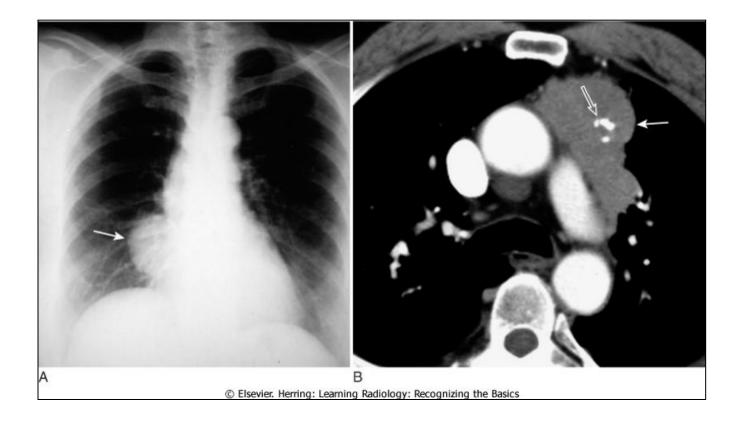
Thymomas, conventional radiograph (A) and CT scan (B). Thymomas are neoplasms of thymic epithelium and lymphocytes that occur most often in middle-aged adults, generally at an older age than those with teratomas. The patient in A has a smoothly contoured anterior mediastinal mass seen on the frontal view (closed white arrow). This patient had myasthenia gravis and improved following resection of the thymoma. Another patient with a thymoma (B) has an anterior mediastinal mass (closed white arrow) that contains some amorphous calcification (open white arrow).
